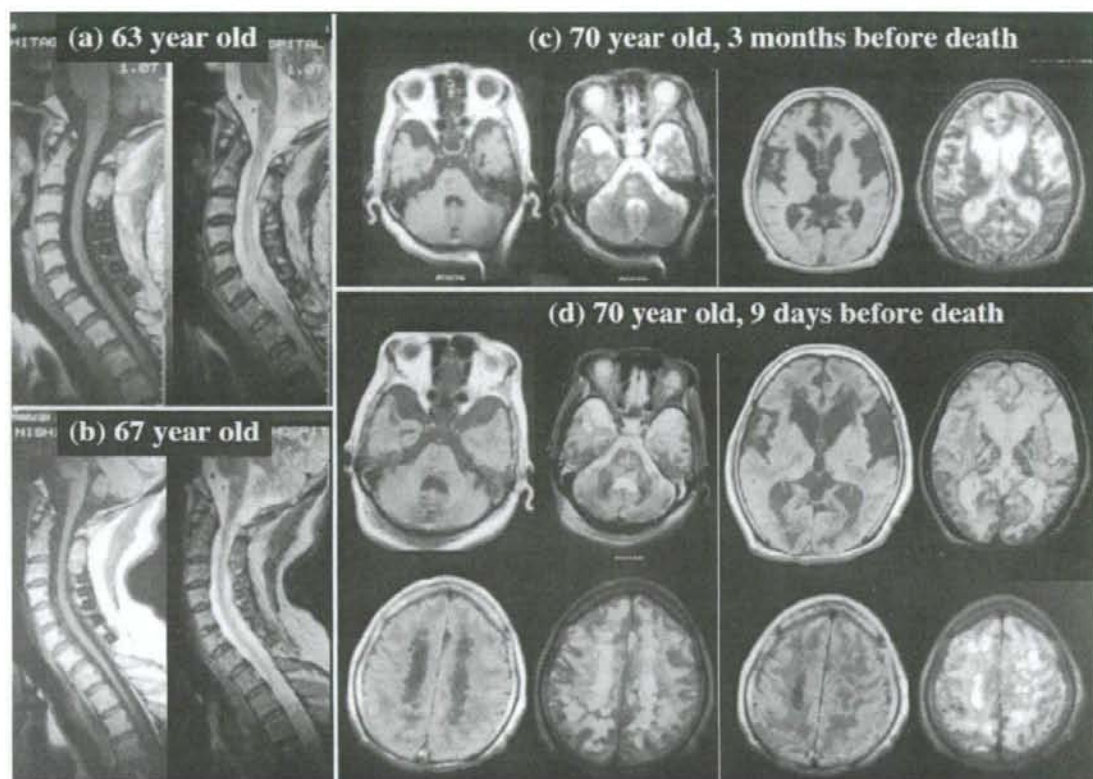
MRI study of the neuromyelitis optica (NMO) patient. The patient developed the initial symptoms at age 57, followed by a relapsing-remitting clinical course, and died at age 70. (a) MRI of the cervical spinal cord at age 63, (b) MRI of the cervical spinal cord at age 67, (c) MRI of the brain at age 70 at 3 months before death, and (d) MRI of the brain at age 70 at 9 days before death. The left panels show T1-weighted images, while the right panels represent the corresponding T2-weighted images.
